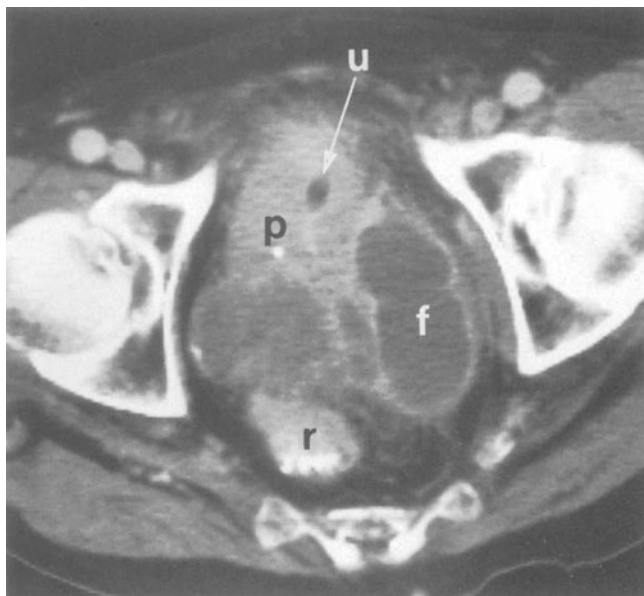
Computed tomography scan demonstrating hypodense areas within the prostate consistent with abscess cavity (Image adapted from Wessels & McAninch “Urologic Emergencies – A Practical Approach” – 2005 Humana Press – Page 138)
